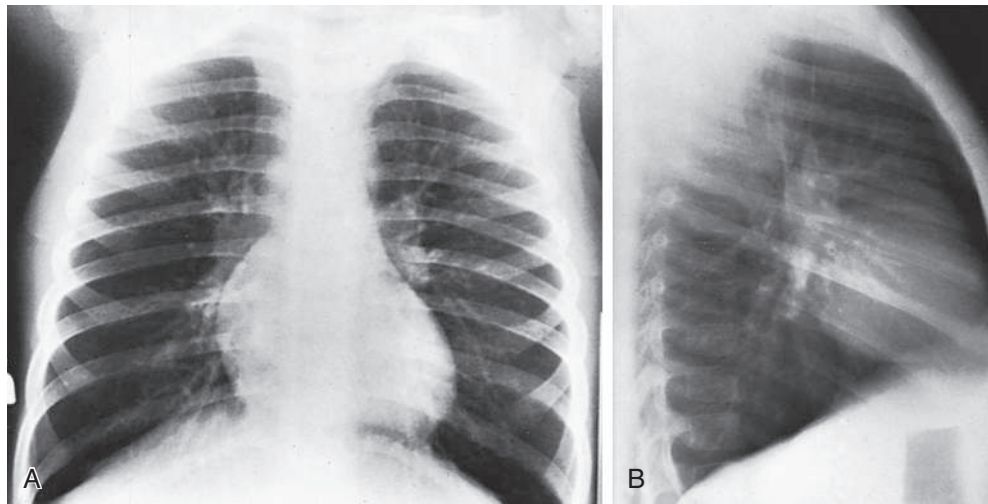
Frontal (A) and lateral (B) radiographs of a 4-year-old with asthma show pulmonary hyperinflation, flattening of the diaphragms, and minimal peribronchial thickening. No asthmatic complication is apparent.
